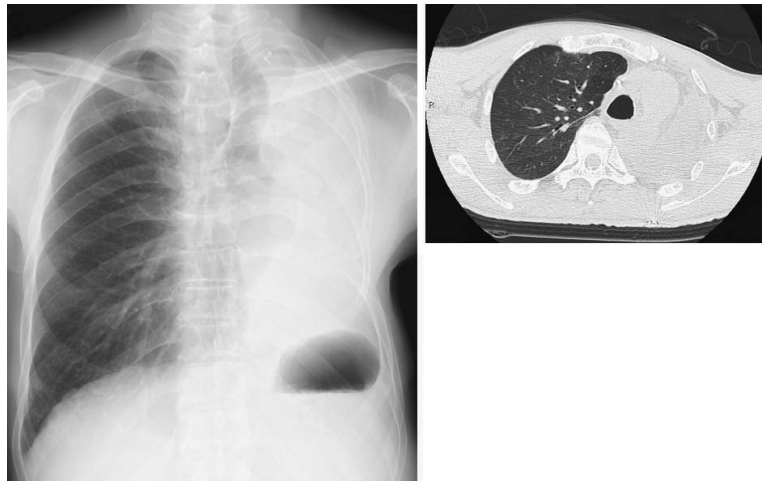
Chest X-ray films 22 days after the left pneumonectomy. Only slight diffuse ground-glass opacity still remained over the right lung.
